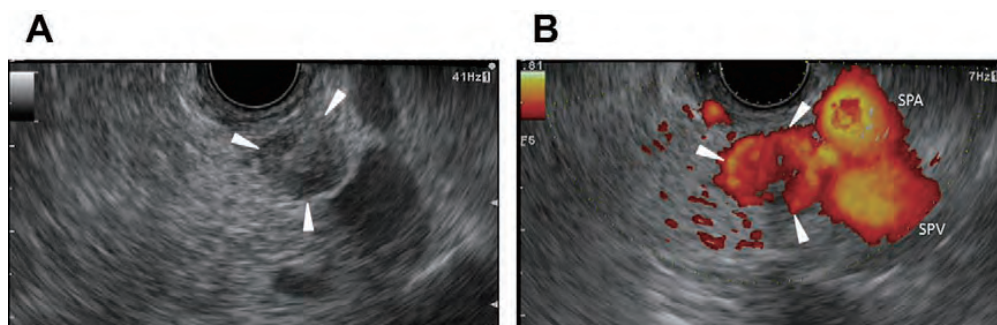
Typical conventional EUS and contrast-enhanced power Doppler EUS images of a small endocrine tumor in the pancreas. (A) The conventional EUS image shows a small hypoechoic nodule (*arrowheads*) of 10 mm in diameter in the body of the pancreas. (B) The contrast-enhanced power Doppler EUS image shows abundant vessels in the nodule (*arrowheads*), although blooming artifact is observed at vessels in the nodule. Blooming artifact is also observed in the splenic artery (SPA) and splenic vein (SPV).
